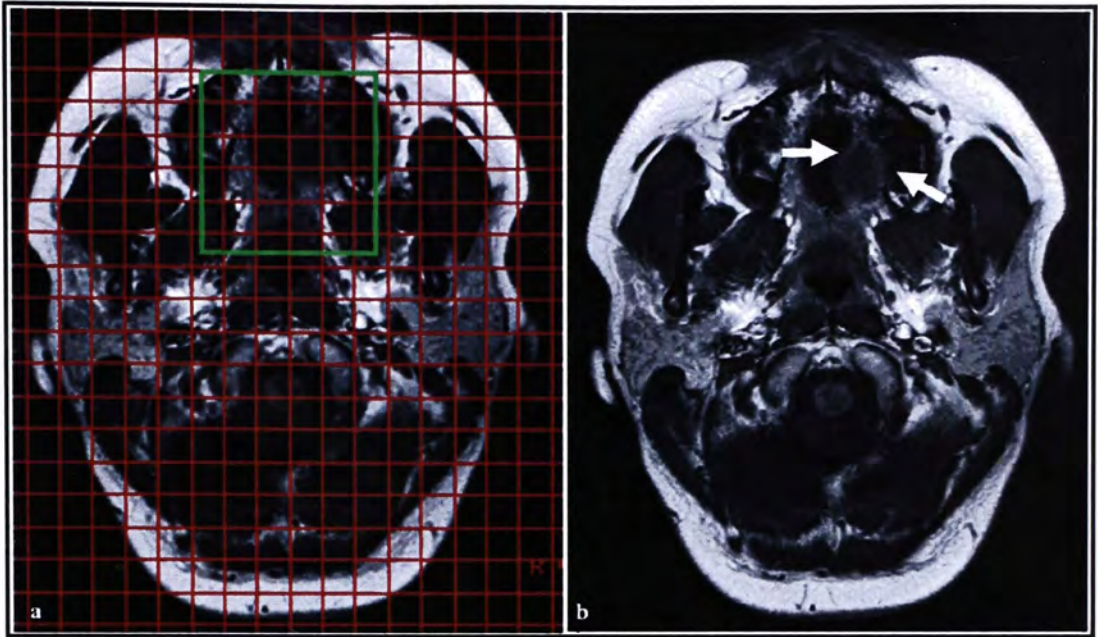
MRI images of a 40-year-old patient with MECa (subject 13).
